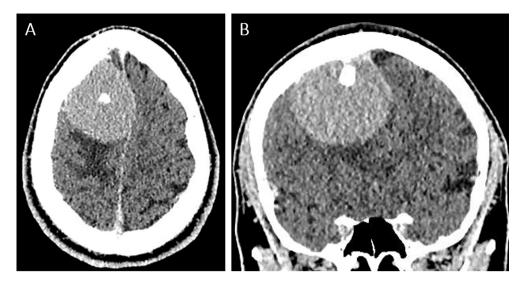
Axial (A) and coronal (B) non-contrast CT scans demonstrating a right frontal meningioma with calcification and mass effect.
